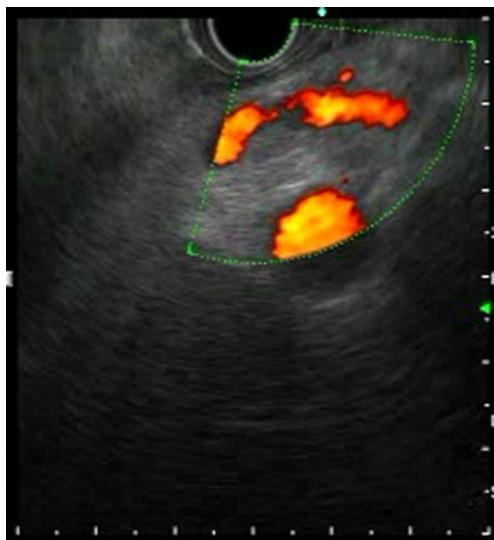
Endoscopic ultrasound Doppler image showing multiple periesophageal collaterals
